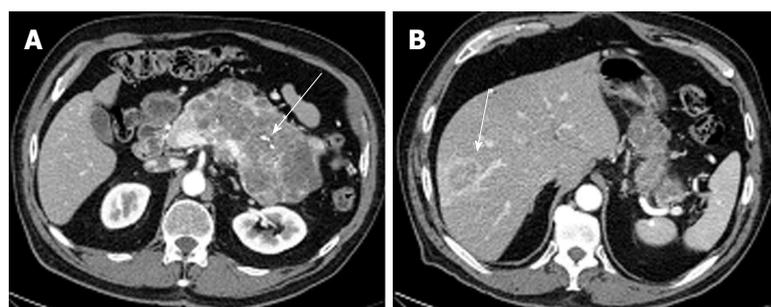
A 78-year-old female with a large serous cystic neoplasm with liver metastasis. A: The pancreatic parenchymal phase of an axial contrast enhanced- computed tomography (CT) demonstrates a large low density mass with patchy enhancement in the body and tail of the pancreas. Central calcification is noted (arrow); B: Axial CT cranial to Figure 11A shows a low density liver mass with peripheral and patchy enhancement in segment VIII (arrow). The appearance is similar to the pancreatic mass.
